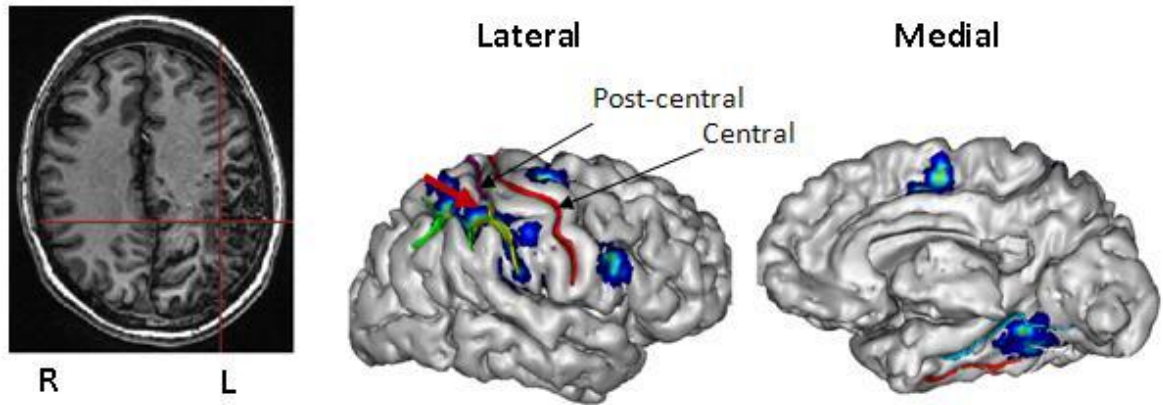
The activation map for hand grasping task of patient P09. Location of the AVM is shown by the red crosshair in the T1-weighted image (shown in radiological orientation) and the cortical mesh. Activation centres are pointed by the red arrow in the lateral views of both hemispheres. Also the region above the cingulate sulcus has been activated in this patient.
